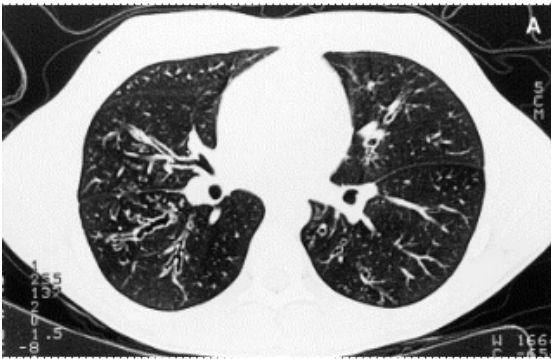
HRCT showing presence of bronchiectasis and peribronchovascular thickening [33].
